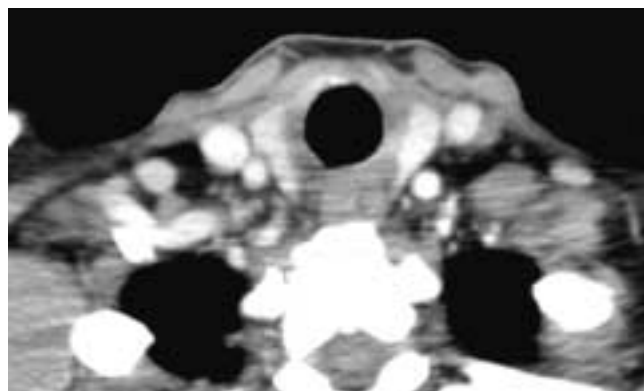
Axial contrast-enhanced CT scan shows a normal tracheal lumen at the level of the uppermost trachea.
